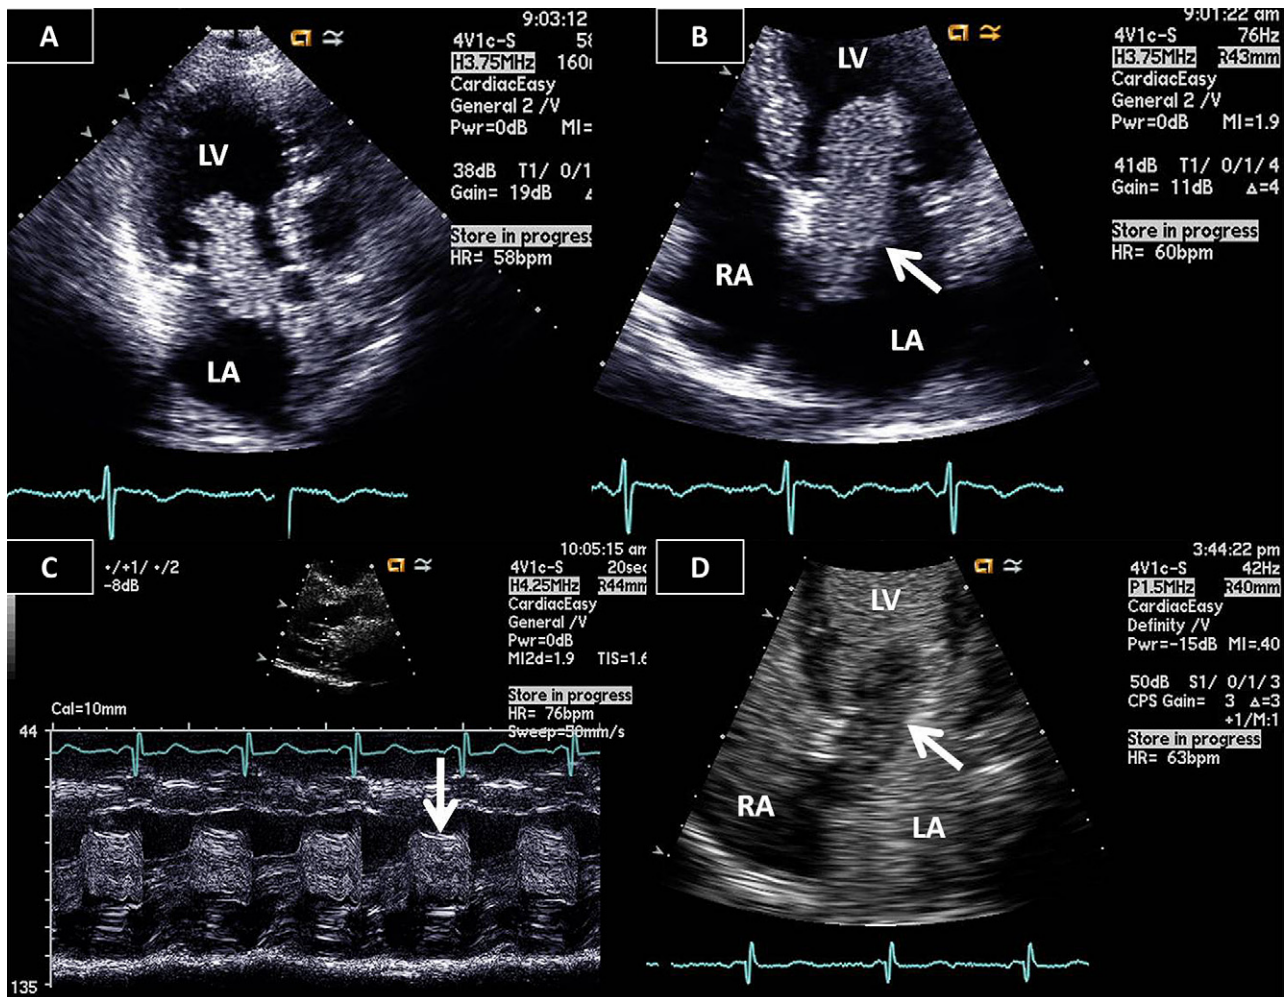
Transthoracic echocardiography. (A) Apical three-chamber view and (B) apical four-chamber view demonstrate a large myxoma (*arrow*) protruding from the left atrium (LA) across the mitral valve into the left ventricle (LV). (C) M-mode recording demonstrates tumor plop during diastole (*arrow*). (D) Heterogeneous uptake of perflutren microbubble contrast by the myxoma (*arrow*). RA, Right atrium.
